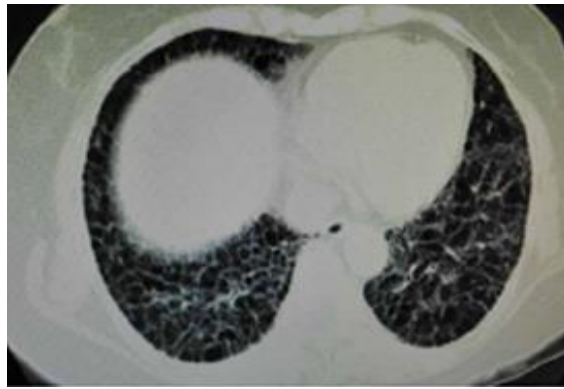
CT-Scan of SS-ILD showing ground glass opacities of lower lobe of both lungs.
